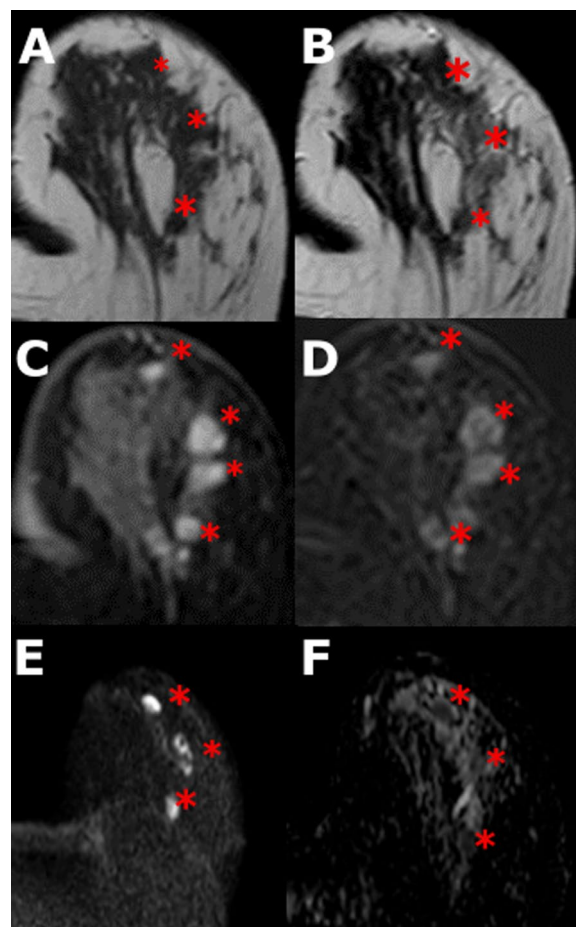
Female patient aged 35 years old complaining of left breast mass with no known family history of breast cancer. MRI revealed: A & B Pre-contrast T1- and T2-weighted axial images showing: multifocal mass of irregular shape and margin seen at the lower half of left breast displaying low signal intensity on T1 and intermediate to low SI on T2-weighted images. C & D Post-contrast dynamic and subtraction axial images showing: heterogeneous enhancing multifocal mass seen at the lower half of the left breast. E & F DWI shows high signal and low signal in the ADC map, with mean lesion ADC value = 0.9×10^{-3} mm/sec and perilesional ADC = 1×10^{-3} mm/s. Pathology proved to be high-grade invasive duct carcinoma—Luminal B HER2-positive subtype—Ki-30%
